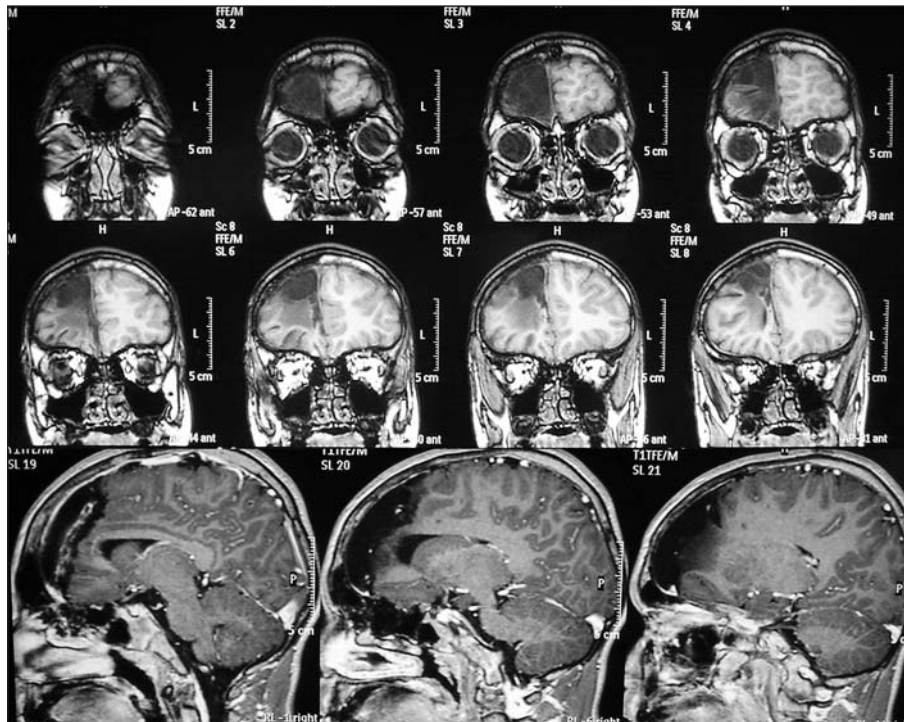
Post-operative MRI showing right frontal cortectomy.
